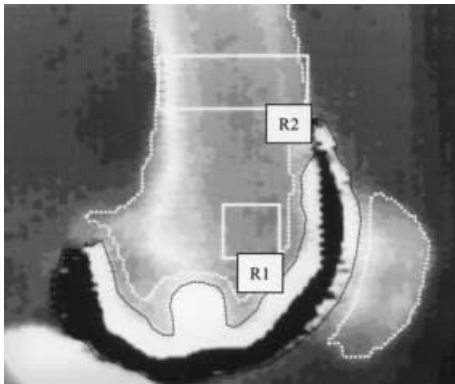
Lateral dual-energy X-ray absorptiometry (DEXA) scan of a distal femur with a femoral component of a TKA, with regions of interest 1 (R1) and 2 (R2)
